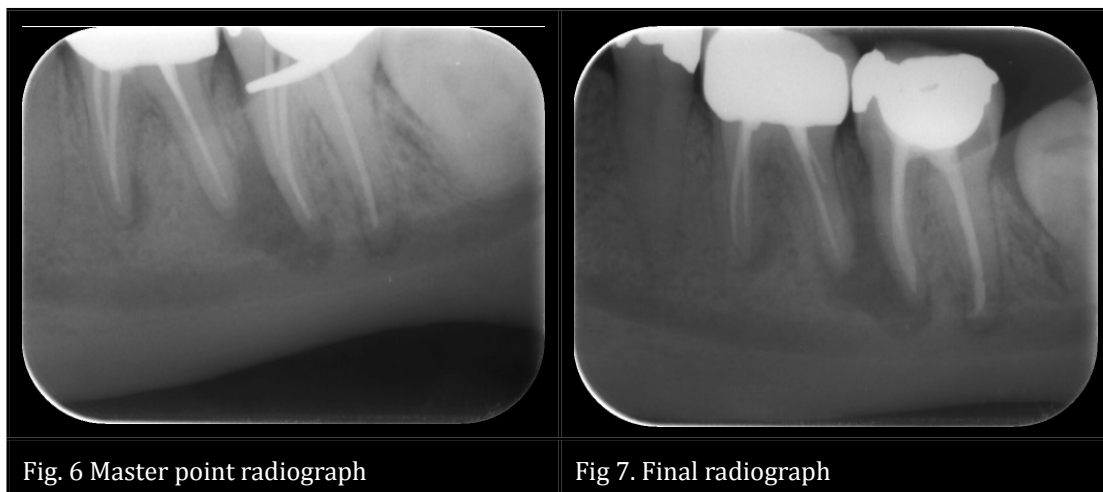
Master point radiograph
